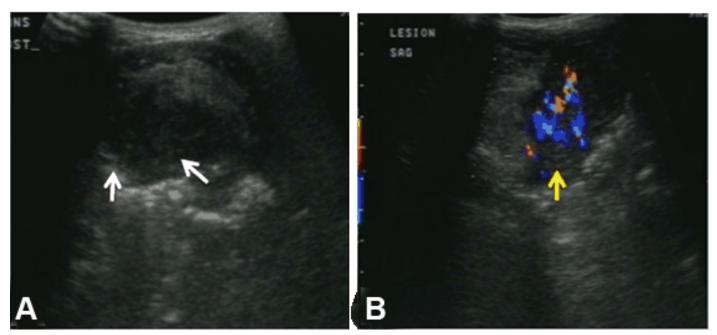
(A) Transverse ultrasound of patient demonstrating a hypoechoic lesion at the base of the tongue (arrows), with clearly delineated margins, (B) Color Doppler ultrasound of the tongue in the same patient showing marked vascularity of the lesion (arrow) compared to the surrounding normal tongue tissue (Case 2).
